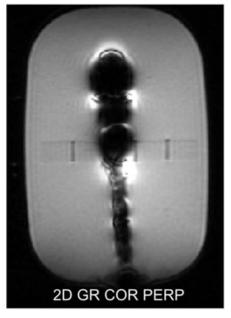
Left: standard VAB needle tip. Right: image artifacts on a needle tip during MR imaging
